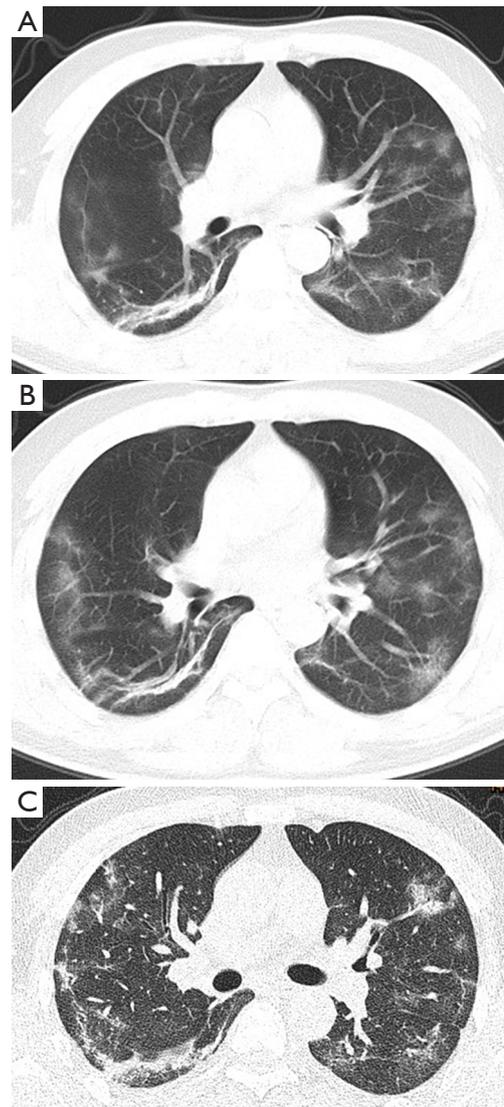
Linear opacities in a 48-year-old male with COVID-19. (A,B) CT images show multiple linear shadows seen in the bilateral lungs. (C) HRCT reveals linear opacities more clearly than standard CT. The opacities are predominantly distributed peripherally. HRCT, high resolution computed tomography.
